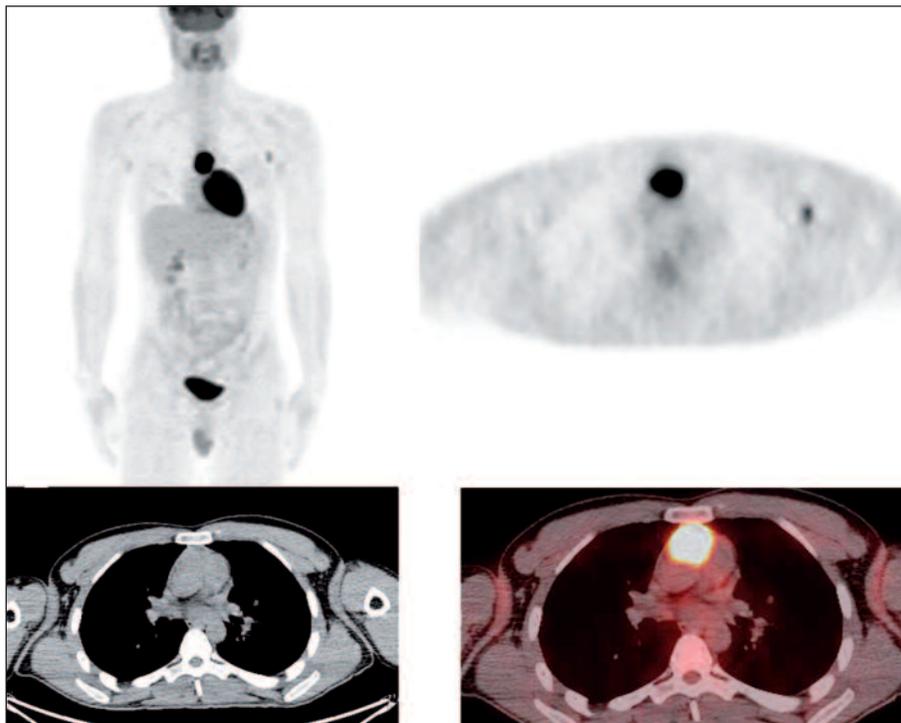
FDG-PET/CT scanning of the patient.
